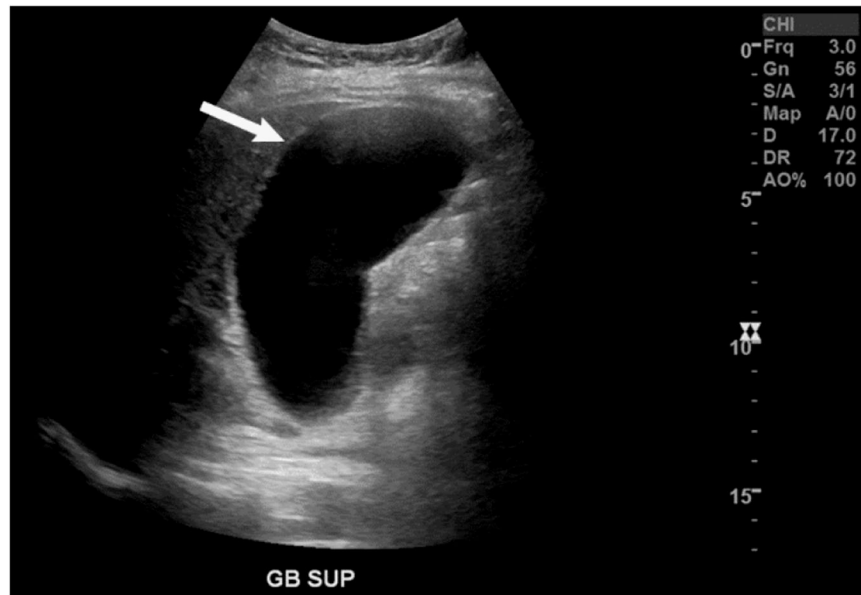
Transabdominal sagittal ultrasound of the gallbladder (arrow) shows marked luminal distension, with long axis measurement of 10 cm.
